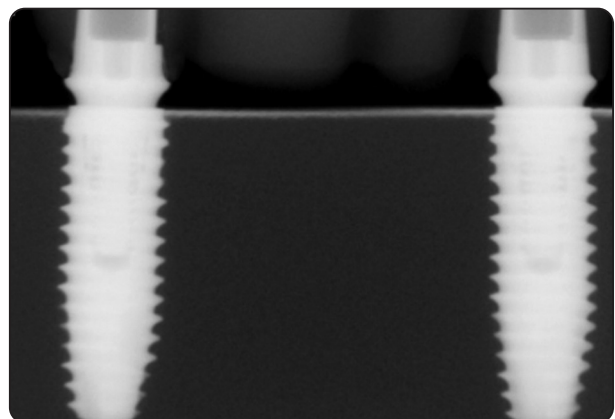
X-ray of The Implants After Insertion.
